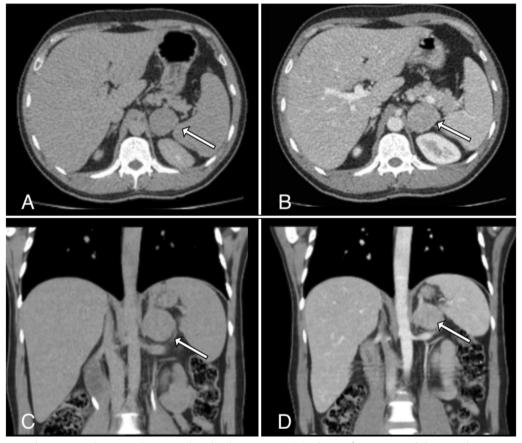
Abdominopelvic computed tomography scan with and without contrast. A Axial view of pre-contrast abdominopelvic computed tomography scan. B Axial view of abdominopelvic computed tomography with contrast. C Coronal view of pre-contrast abdominopelvic computed tomography scan. D Coronal view of abdominopelvic computed tomography with contrast. A and C demonstrated a 4 cm mass in the left adrenal gland (arrow). B and D showed mass enhancement with contrast (arrow)
